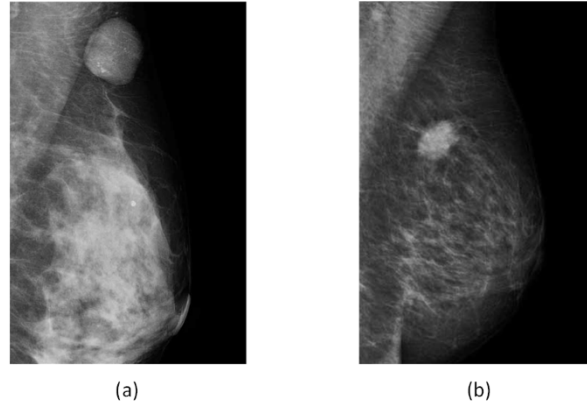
The X-ray mammogram. (a) Example of a digital mammogram image measured on a breast containing a benign pathology, it is worth noting the regularity of the margins. (b) A digital mammogram image measured on a cancerous breast, the tumor presents irregular margins.
